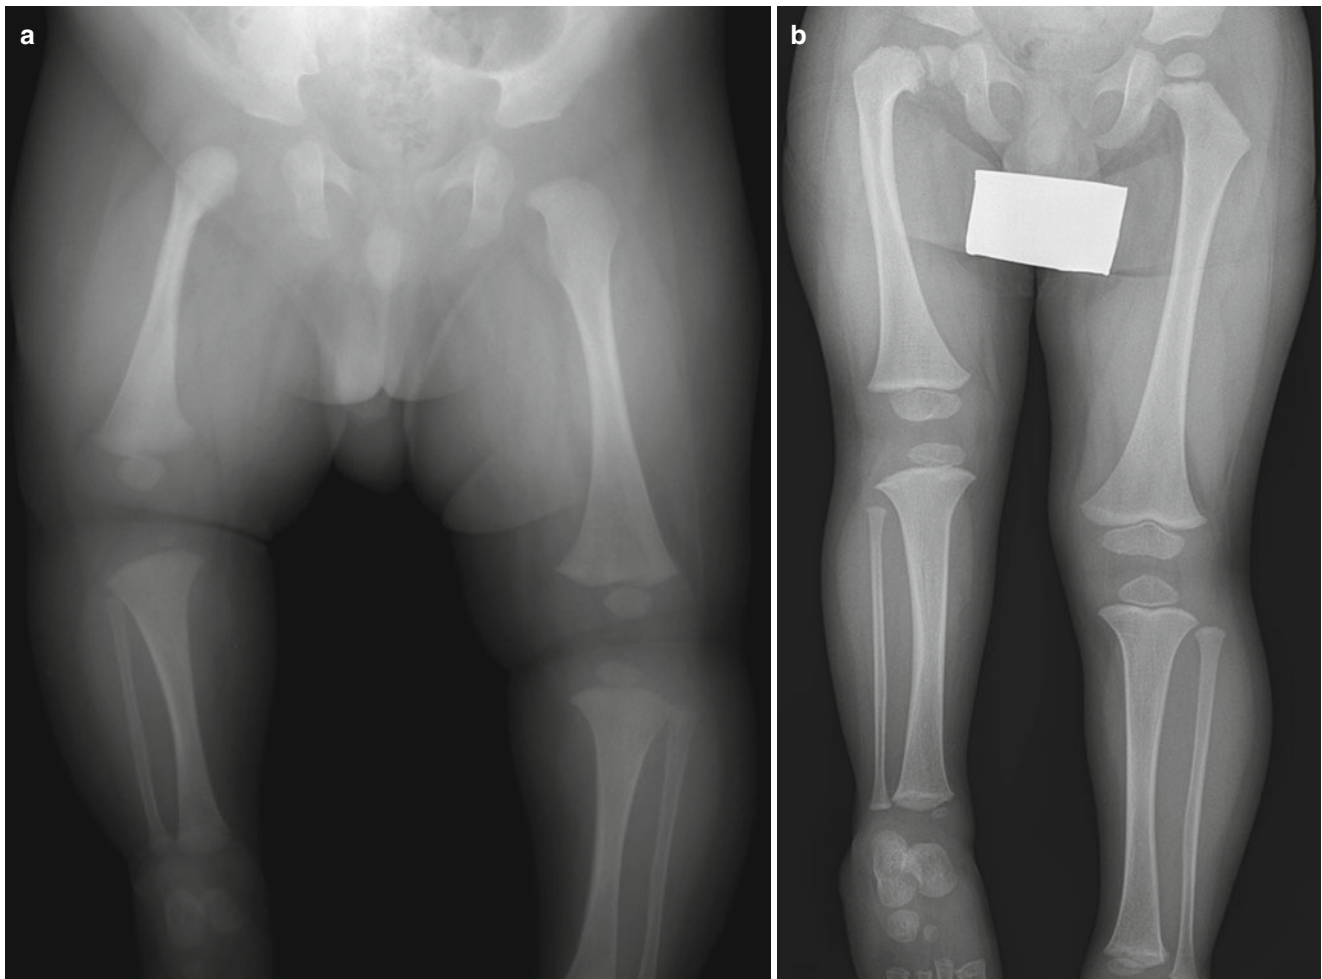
Proximal femoral focal deficiency. (a) Anteroposterior radiograph of a 4-month-old infant with a short right femur shows hypoplastic right femur. Right acetabulum is relatively normal. (b)
